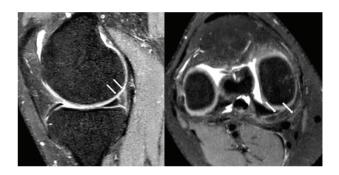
Magnetic resonance imaging sections with a Greif type 5 lesion ramp. T2-weighted sagittal section with ramp lesion (left). T2-weighted axial section with ramp lesion. Arrows represent the peripheral posterior horn meniscal double tear (right and left).
